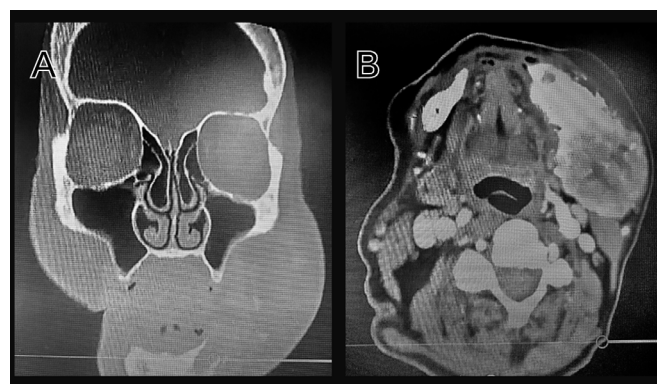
Radiographic features of metastatic tumors. (A, B). Computed Tomography imaging demonstrated a mandibular lesion consistent with metastatic breast carcinoma, with a reported evolution of approximately one year. Courtesy: Dr. Claudia Patricia Peña Vega.
